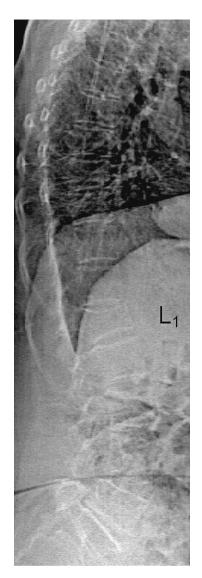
Grade 2 wedge fracture of L1 on a dual-energy X-ray absorptiometry scan.
